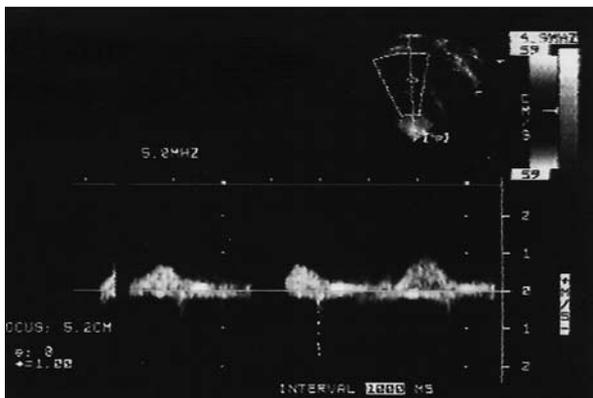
Postoperative, 4 chamber view, using Doppler waves at tricuspid valve regurgitation jet, showing a peak systolic flow of 10 mm Hg
